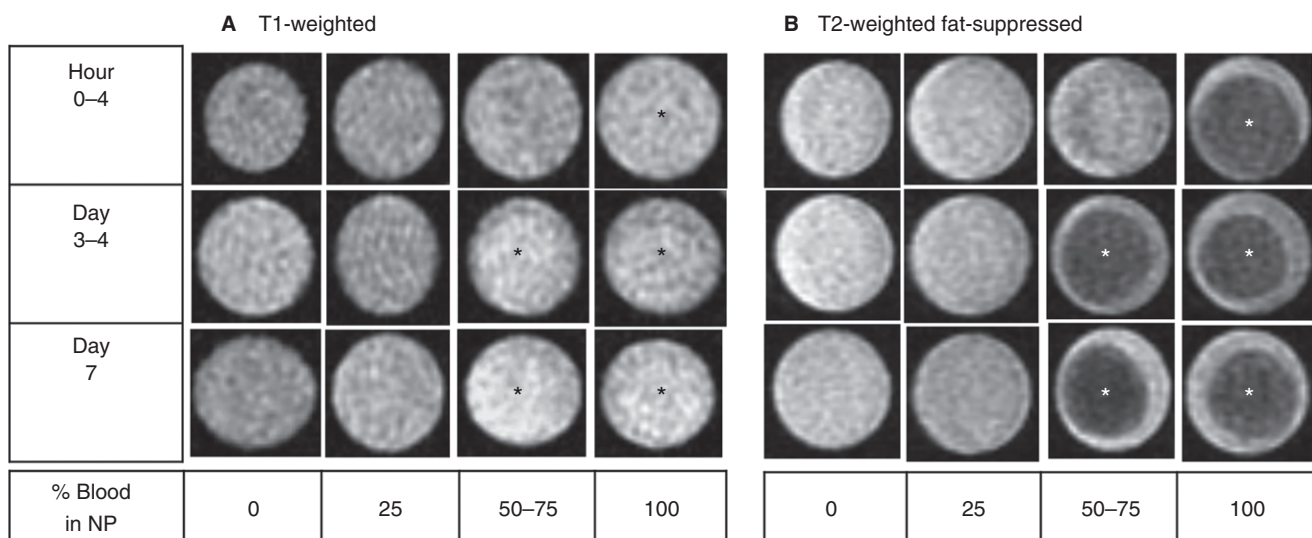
Time -course of MRI appearance of blood dilutions and clotted blood *in vitro*. NP, enriched with 2 mg mL^{-1} hyaluronic acid, was diluted with increasing concentrations of freshly drawn human blood (3–6-mL syringes) and subjected to serial conventional MRI at the indicated time-points. (A) T1-weighted MR images with identical window level and width. (B) T2-weighted fat-suppressed MR images with identical window level and width. Asterisk: blood clots. Conventional MRI did not discriminate between the presence and absence of blood. Increasing blood concentrations did not change signal intensity qualitatively in T1- and T2-weighted fat-suppressed images. Blood clots were most easily distinguishable on the T2-weighted fat-suppressed images because they were hypointense relative to surrounding serosanguinous fluid, but were also faintly observable as hyperchoic on the T1-weighted images after day 3. NP, normal pooled plasma; MRI, magnetic resonance imaging.
